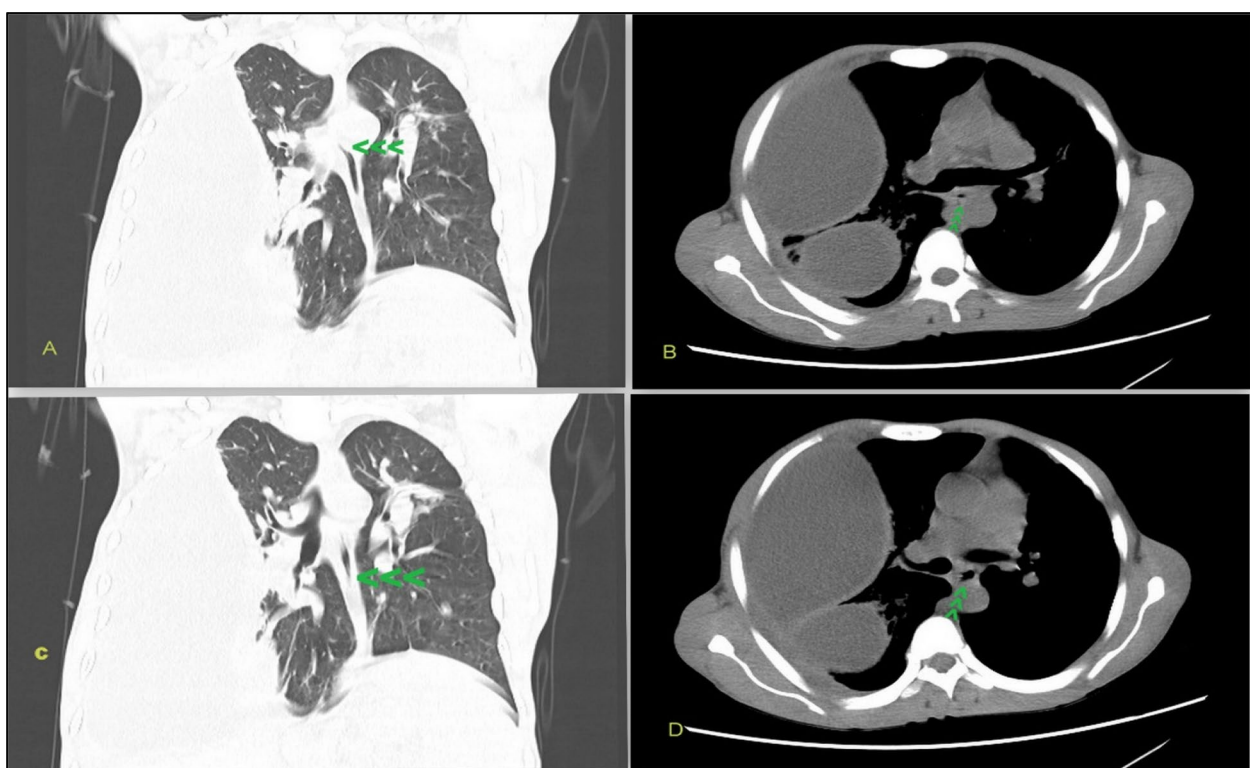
(A) Coronal and (B) axial plane non-contrast computed tomography scan with the green arrow heads showing cardiac bronchus originating from the medial aspect of bronchus intermedius and descending medially and leftward ending blindly without supplying any lung tissue (C, D)
